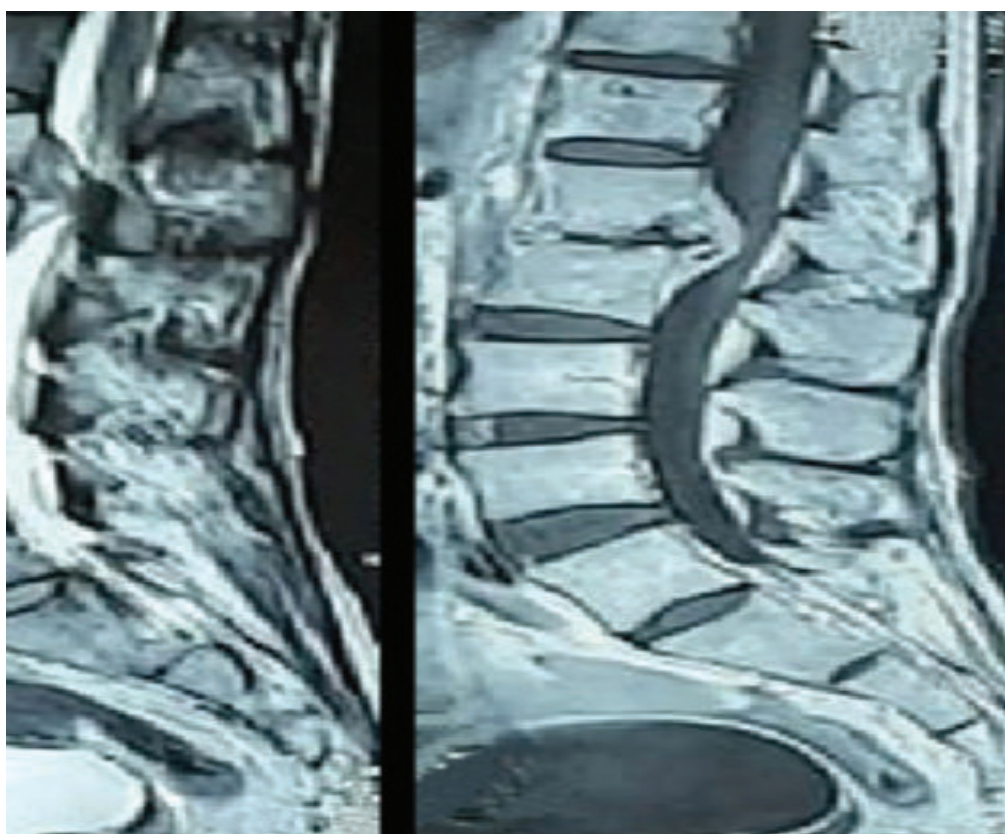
MRI of lumbosacral spine T1-weighted and T2-weighted and T1+C sagittal images of the patient
